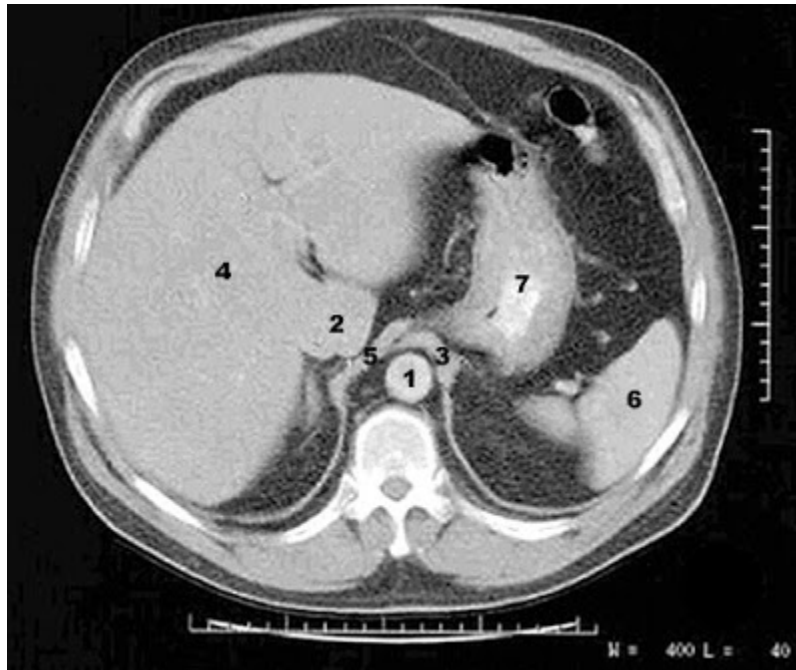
CT scan of the abdomen showing the liver in cross section
